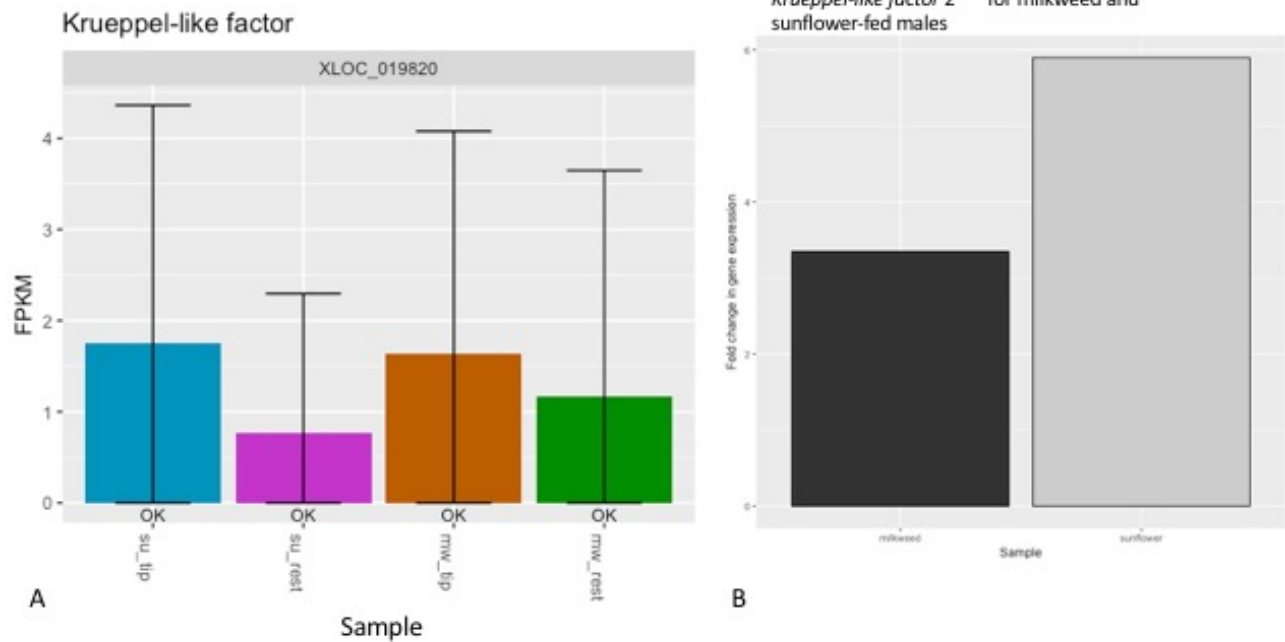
krueppel-like factor* is not favored in one treatment over another. (A) Fragment per kilobase million (FPKM) counts for each sample and the (B) $2^{-\Delta CT}$ measurements for *krueppel-like factor*. The FPKM (A) shows the relative amount of expression per sample; error bars represent the confidence interval for each sample. None of the samples are favored over any of the others. The $2^{-\Delta CT}$ values (B) are close to each other, and have a slight lean towards sunflower-fed males.
